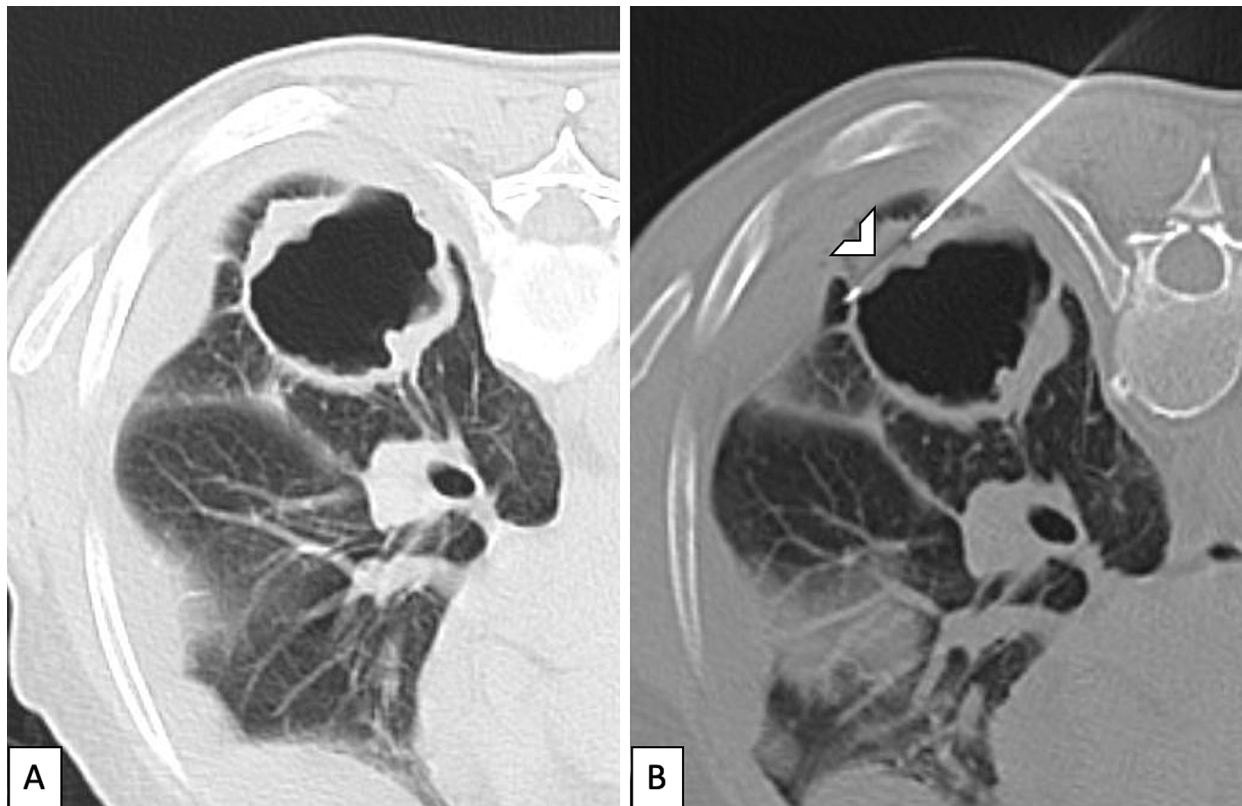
A-B. CT-guided transthoracic core needle biopsy of a cavitary lesion located in the right lower lobe. B. The biopsy groove (arrowhead) was aligned with the wall thickening to maximize tissue sampling (i.e., tangential approach). The final diagnosis was non-small cell lung cancer favor squamous carcinoma.
